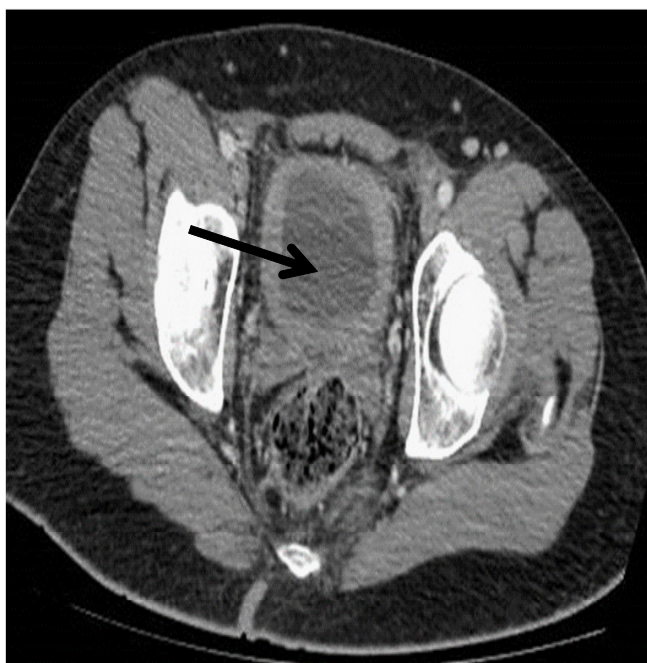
CT (Computed Tomography) images of Thorax, abdomen and Pelvis showing urinary bladder diffuse thickening.
